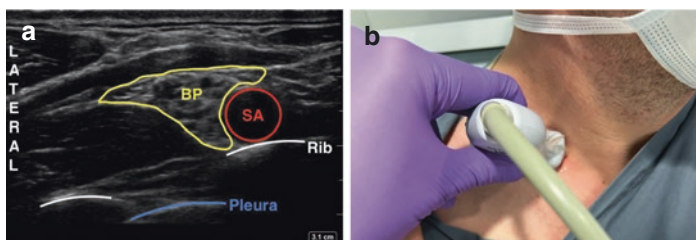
(a) Ultrasound image of supraclavicular approach to brachial plexus nerve blocks. *BP* Brachial plexus, *SA* subclavian artery. (b) Ultrasound probe placement to obtain supraclavicular view
